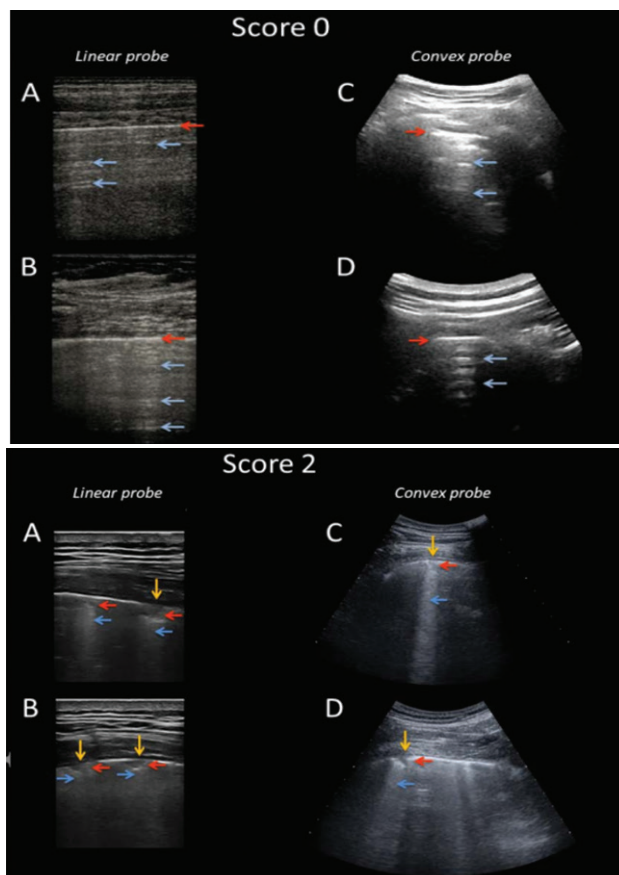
Ultrasound based scoring⁸
